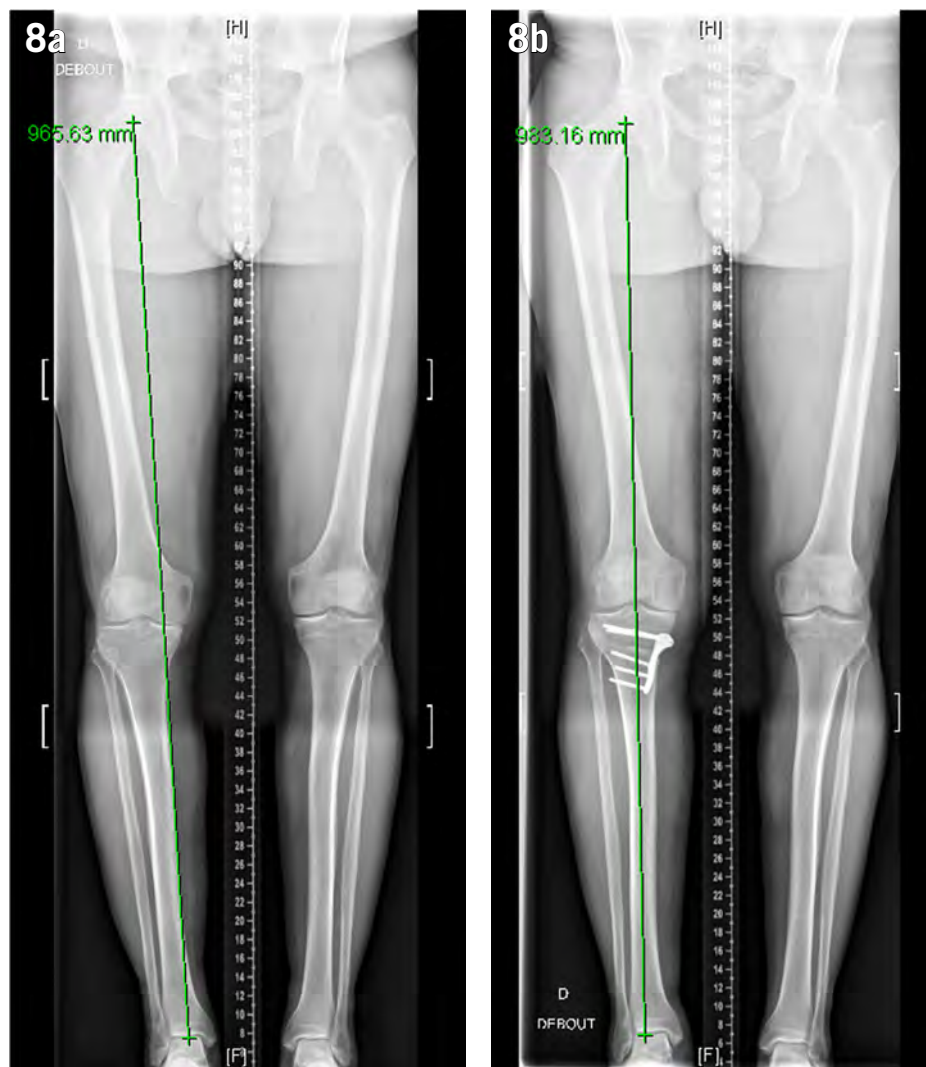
(a and b) Pre-operative and postoperative x-rays of the Case 1.
